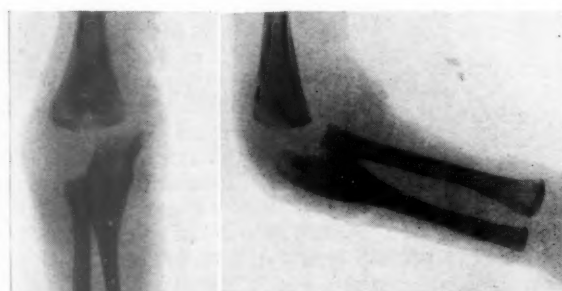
Radiograph of osteomyelitis at proximal end of ulna and periosteal regeneration of bone of ulna and humerus.
